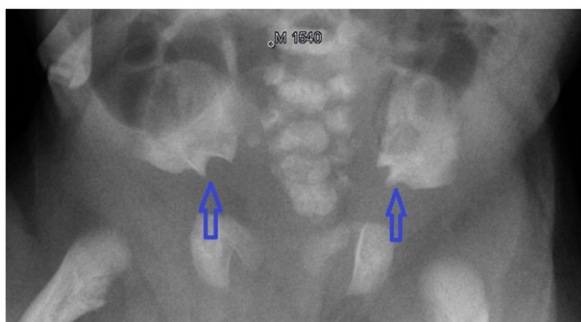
Radiograph of the patient's pelvis. Arrows pointing at the trident acetabula.
